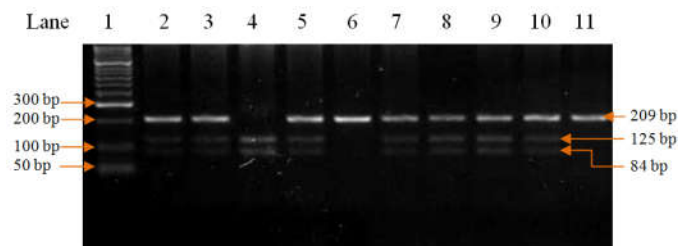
Gel picture shows the PCR-RFLP analysis; after digestion of PCR product with *MaeIII* restriction enzymes; Lane 1: 100 bp DNA ladder; Lane 2, 3, 5, 7, 8, 9, 10: Heterozygous CT genotype; Lane 4: Homozygous CC genotype; Lane 6, 11: Homozygous TT genotype
